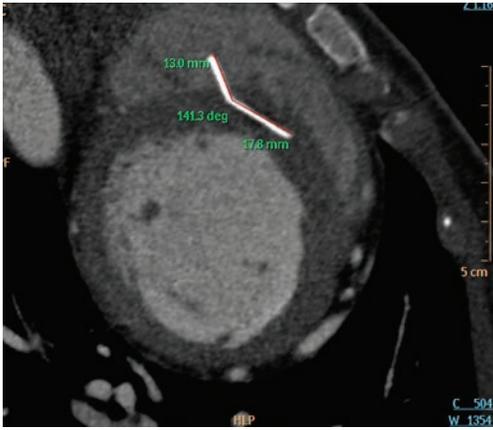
Cardiac multidetector computed tomography (MDCT). Cardiac MDCT revealed that about two-thirds of the metallic wire was embedded in the muscular interventricular septum and one-third extended into the right ventricular cavity. The wire did not extend into the left ventricular cavity. However, it did bend during systole and straighten during diastole (Online Videos 3 and 4).
